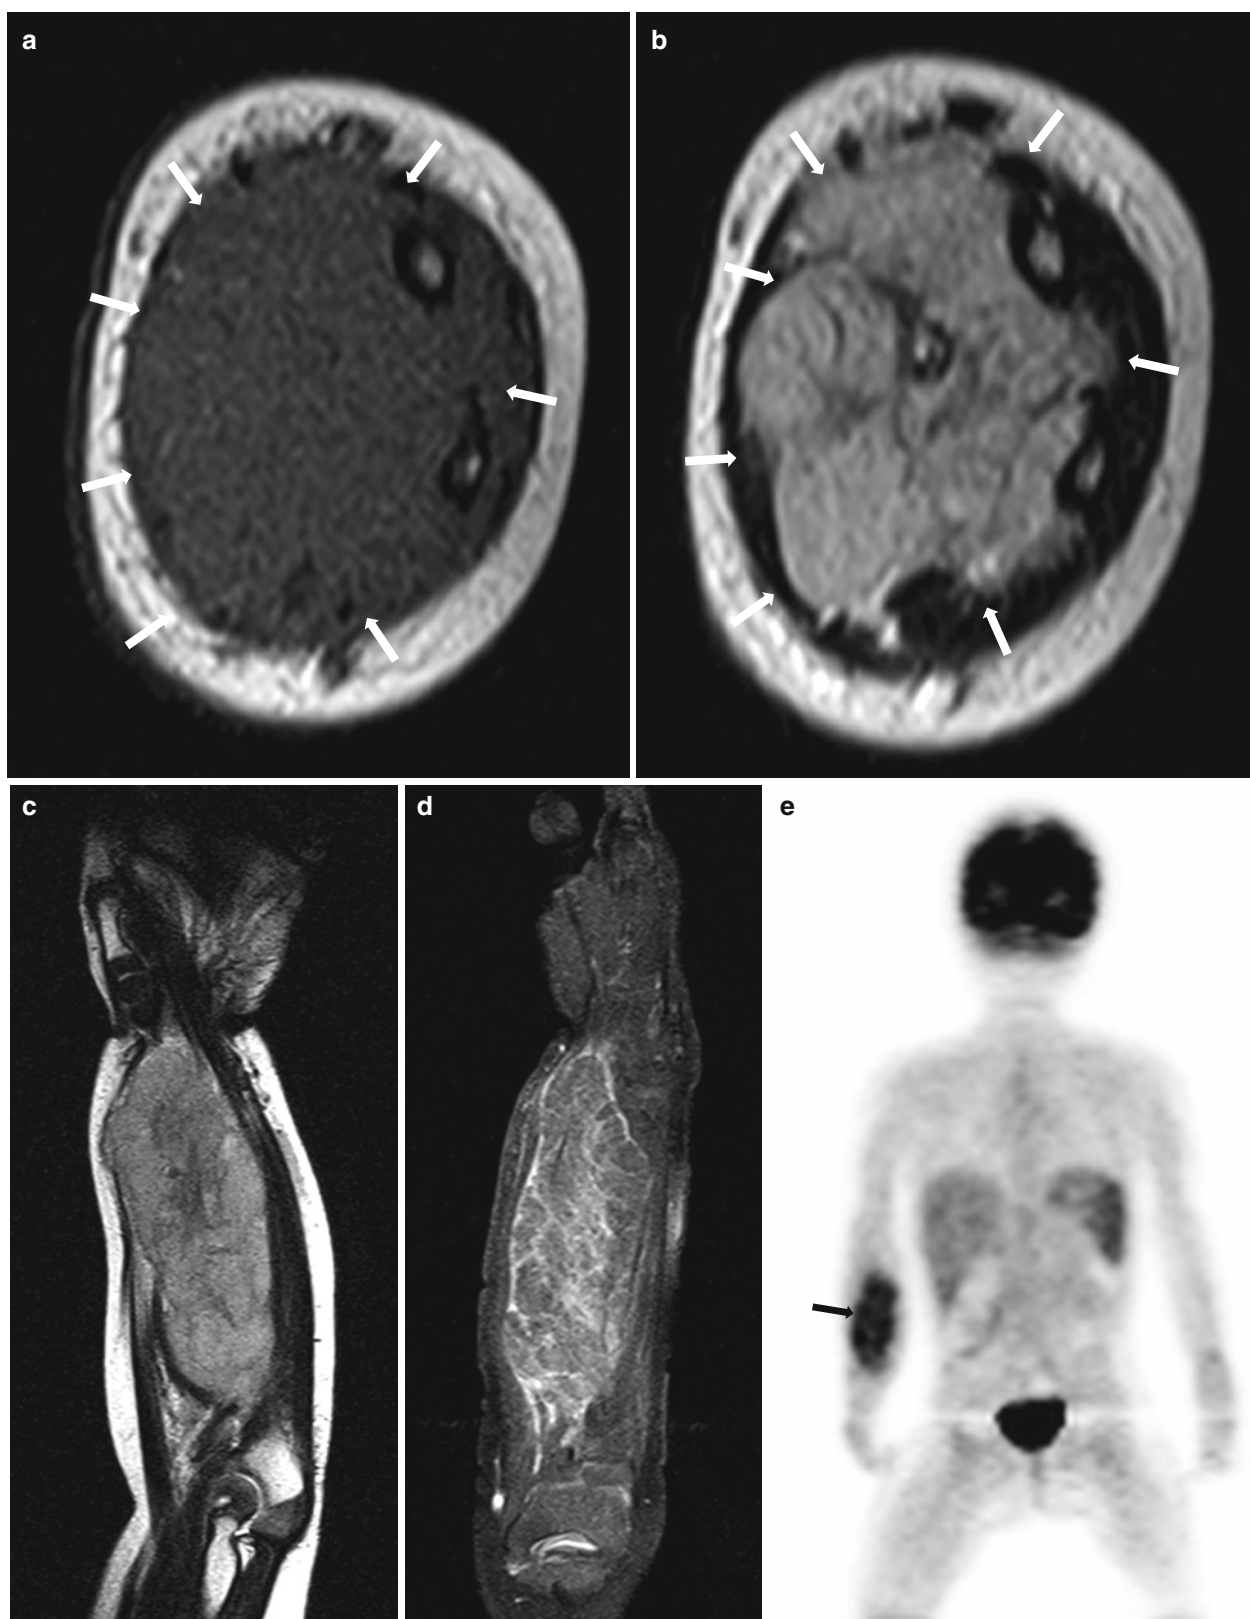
Rhabdomyosarcoma in the arm of a 1-year-old boy. (a) Axial T1-weighted MR image shows a mass (*arrows*) with isointense signal intensity compared to muscle. (b) Axial T2-weighted MR image of the mass (*arrows*) shows heterogeneous hyperintense signal compared to muscle. (c) Coronal T2-weighted MR image shows elongated
